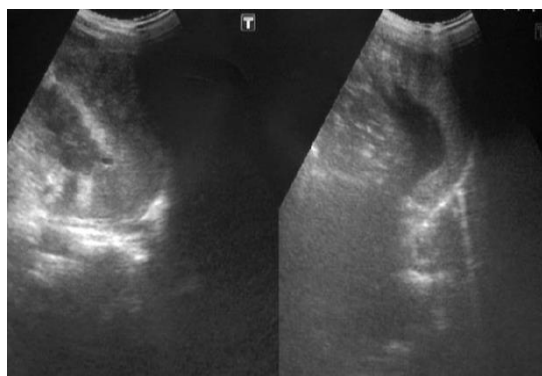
Chronic myeloid leukemia - ultrasonography
